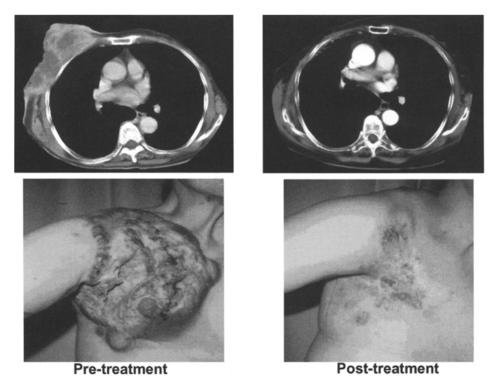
Pre-treatment and post-treatment CT scans from a 71-year-old woman with T4N3M1 (bone) breast cancer treated with 56 Gy breast irradiation and palliative-dose radiation to bone metastases with 4 courses of weekly docetaxel. She remains alive 2 years and 5 months post-treatment.
